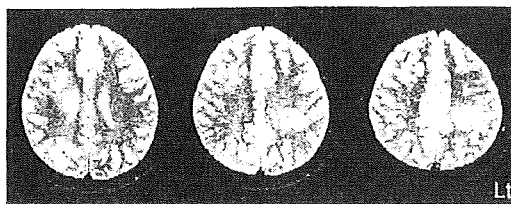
Development of large white matter lesions in a case of neuromyelitis optica (NMO) 2 months after starting interferon- β . This young female patient was aquaporin 4 antibody-positive and showed a clinical and radiological picture characteristic of NMO. However, two months after starting interferon- β 1b treatment, she developed signs of brain hemispheres and MRI showed multiple large white matter lesions.
